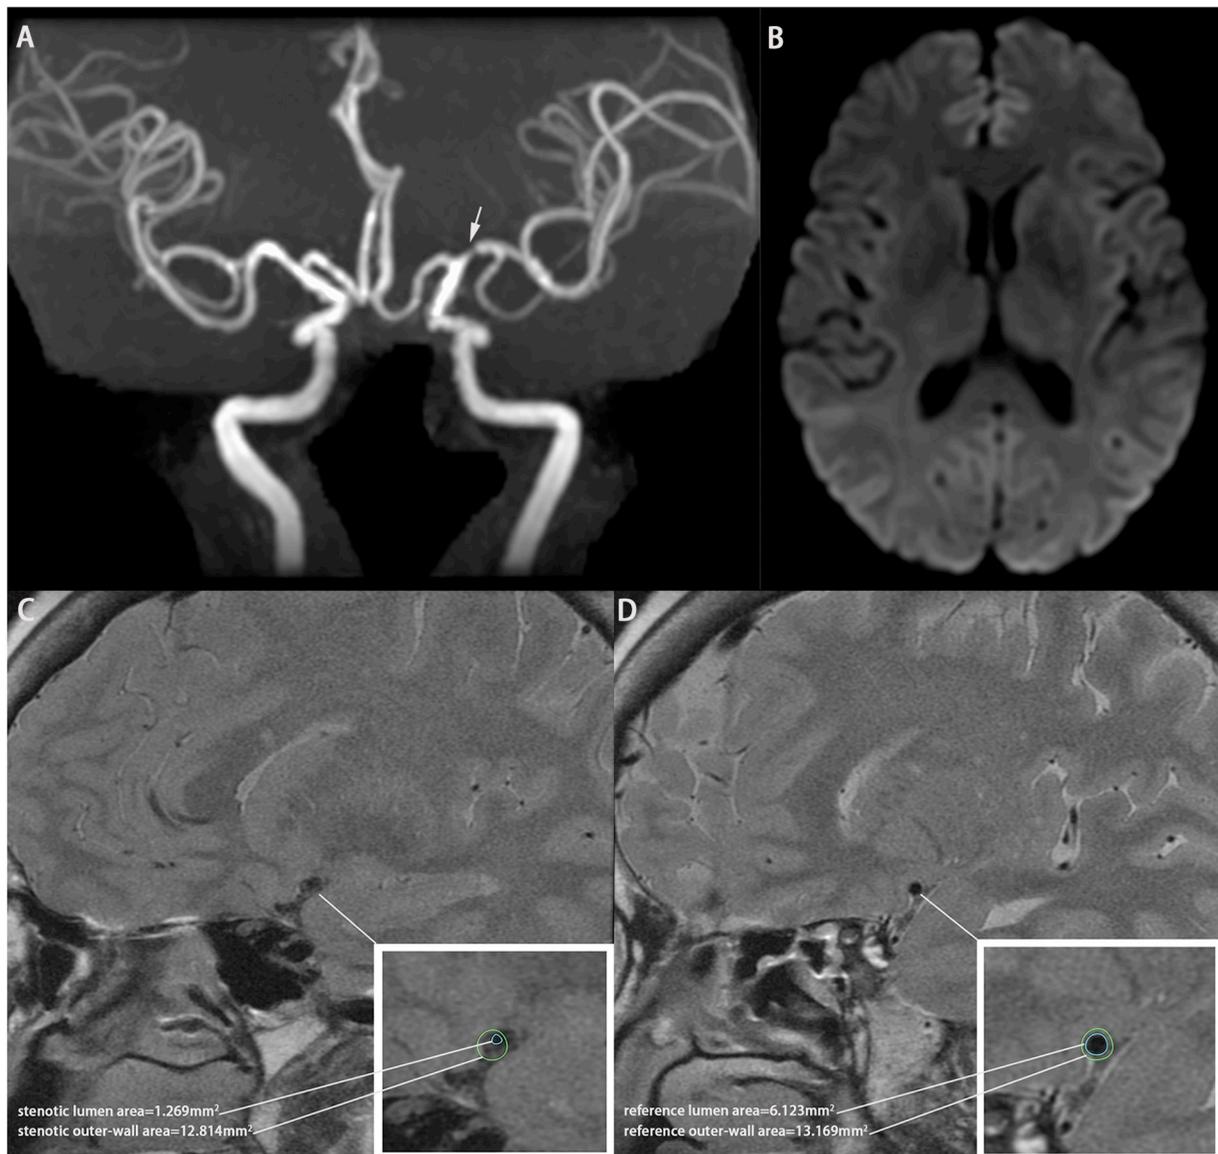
An example of the quantitative measurements of an eccentric asymptomatic plaque. A 60 years old woman with hypertension, diabetes mellitus and hyperlipidemia had left MCA stenosis(A) and did not have a lesion on diffusion weighted imaging(B). (C) and (D) show the quantitative measurements of the asymptomatic eccentric plaque at the maximal stenotic site(C) and the reference site(D) on high-resolution T2-weighted imaging sequence, respectively. Plaque length = 3 slices. $SPS = 2.562 (< 2.79)$ indicates an asymptomatic plaque.
